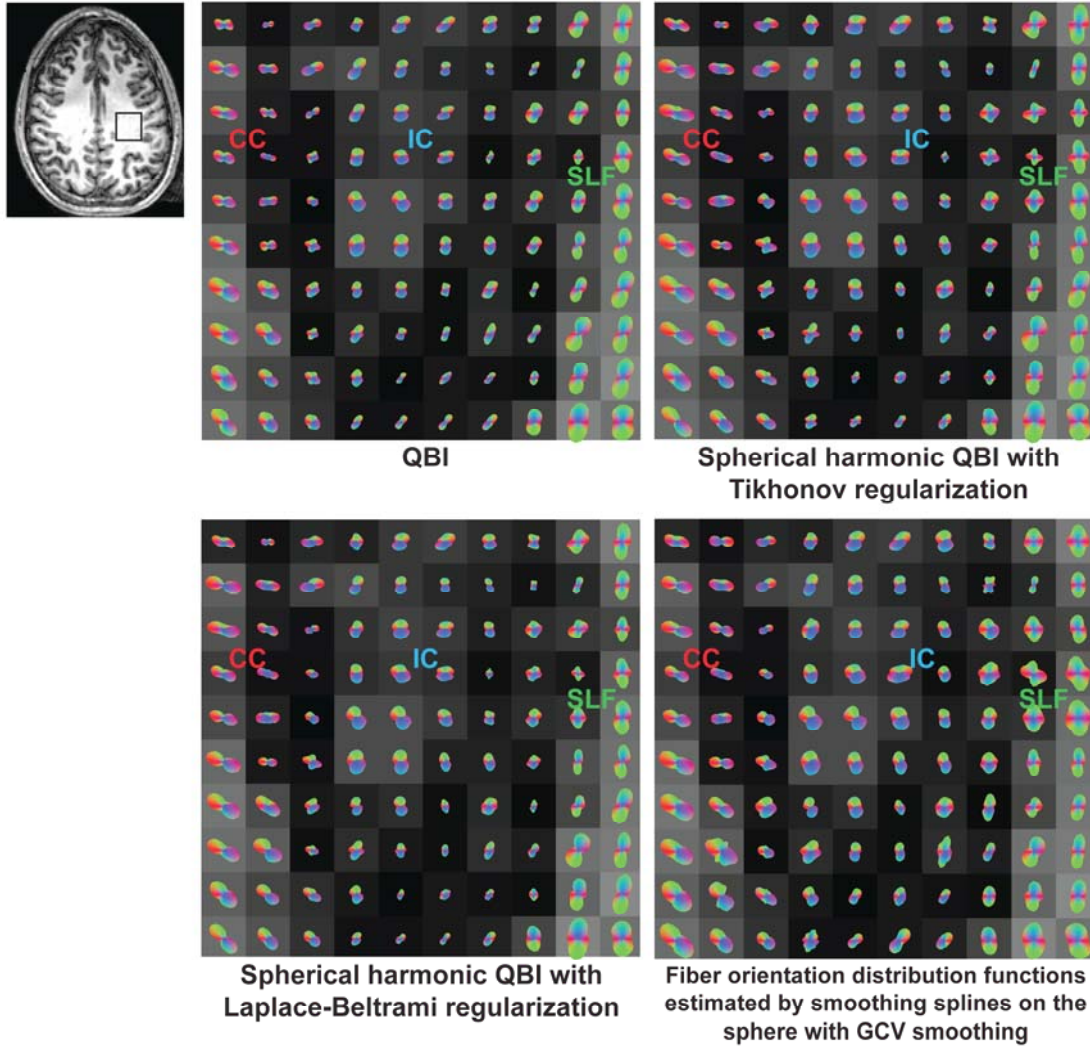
In vivo diffusion-weighted data sampled with 60 directions at $b = 2000$ s/mm^2 with a region-of-interest (ROI) outlined in black in the parietal lobe where projections from the corpus callosum (CC) meet fiber projections from the internal capsule (IC) in the inferior-superior direction and posterior-anterior fibers of the superior longitudinal fasciculus (SLF) on the T1-weighted MPRAGE image of the volunteer, upper left image. All methods are comparable depicting the underlying directionality in the data in the CC, showing fibers oriented in the left-right directions (encoded in red) and for the IC oriented in the inferior-superior directions (encoded in blue). The regularization parameter values $\lambda = 2$ and $\lambda = 0.006$ were used in the reconstruction of the spherical harmonic QBI ODFs with Tikhonov regularization and Laplace-Beltrami regularization, respectively. Spherical harmonic QBI ODFs with Laplace-Beltrami regularization and smoothing splines ODFs in the SLF region show more prominent ODFs indicating potential fiber crossings, in the upper right corner of the respective panesl. This potential crossing is a little less obvious in the SLF QBI ODFs of analytical QBI.
